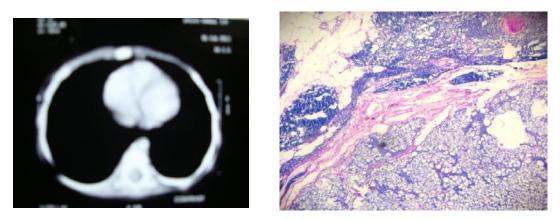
Anterior Mediastinal mass on CT. Fig 4: Pleomorphic, hyper chromatic small round
